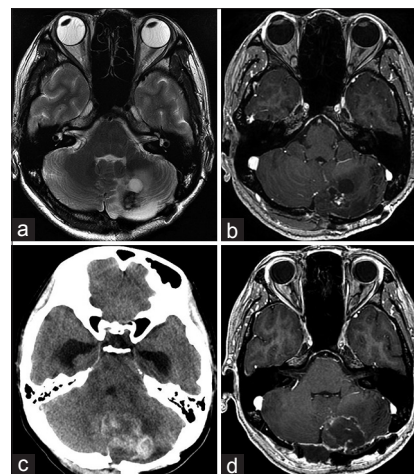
Axial T2-weighted MR image (a) and postcontrast T1-weighted MR image (b) demonstrating appearance of the enhanced lesion adjacent to the cyst formation in the left cerebellar hemisphere at 7 years after second radiosurgery. (c) CT scan showing an irregularly shaped, mixed density lesion with extensive edema in the left cerebellar hemisphere. (d) Postoperative gadolinium-enhanced T1-weighted MR image demonstrating total removal of the lesion
